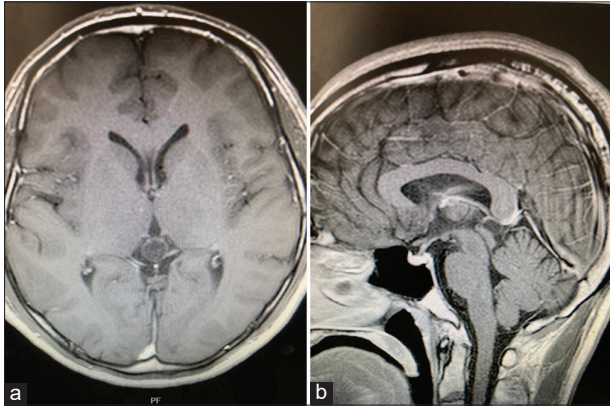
(a) Preoperative axial T1 MR imaging revealing posterior third ventricular lesion. (b) Preoperative sagittal T1 MR imaging revealing posterior third ventricular lesion.
